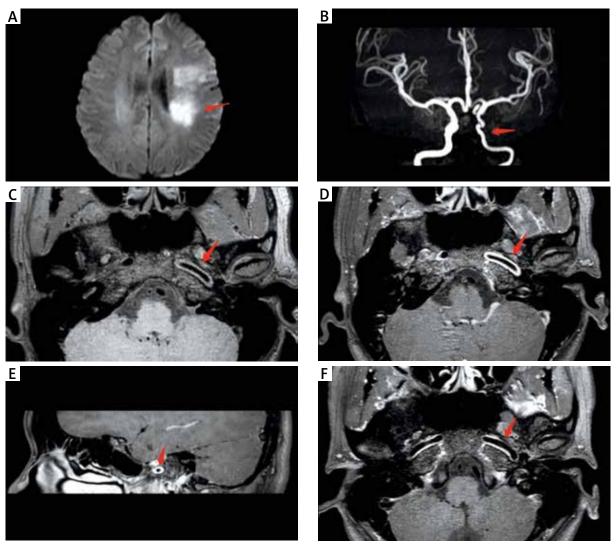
Typical cases of remission after treatment of CNS vasculitis. The patient is a 36-year-old female. A) DWI showing acute infarction of the left radiation coronary artery; B) 3D-TOF MRA showing the thin left internal carotid artery; C-E) HR-MRI showing uniform centripetal thickening of the wall of C2-3 segment of the left internal carotid artery with grade 2 enhancement, corresponding to mild stenosis of the lumen; F) HR-MRI T1WI enhanced image after hormone treatment showing reduced wall enhancement and thickening.
